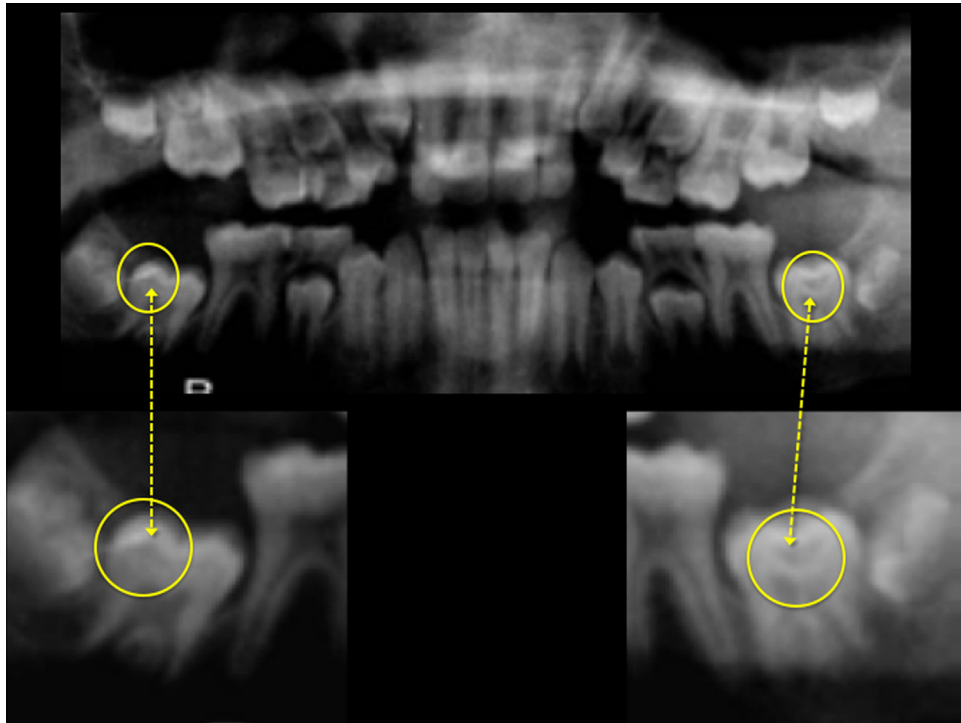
Example of Pre-eruptive intracoronal radiolucency (PIR). Panoramic radiograph of a 10-year-old patient with radiolucencies observable on both unerupted second permanent mandibular molars.
